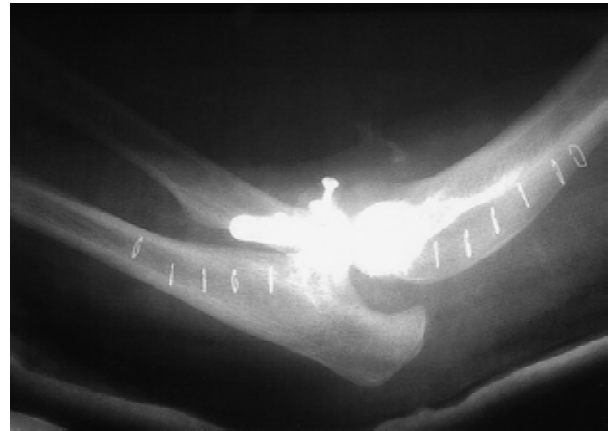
This patient experienced bilateral "terrible triad" injuries in a fall off of a building. The lateral radiograph taken before surgery of the right elbow reveals posterior subluxation of the joint. The treating surgeon fixed the complex radial head/neck fracture in a shortened position and did not repair the lateral soft-tissue structures. It is this revision situation that an articulated hinge fixator is most useful.
